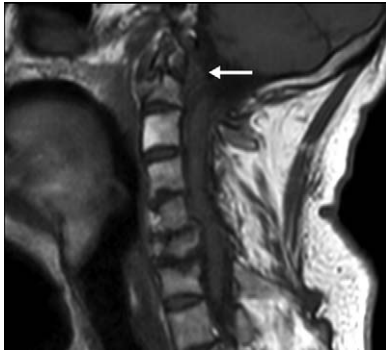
MRI of the cervical spine with pre-contrast and post-contrast T1W images show intense contrast enhancement (arrows) of pannus formation behind the odontoid process indicated inflammation of the right atlantoaxial joint.
